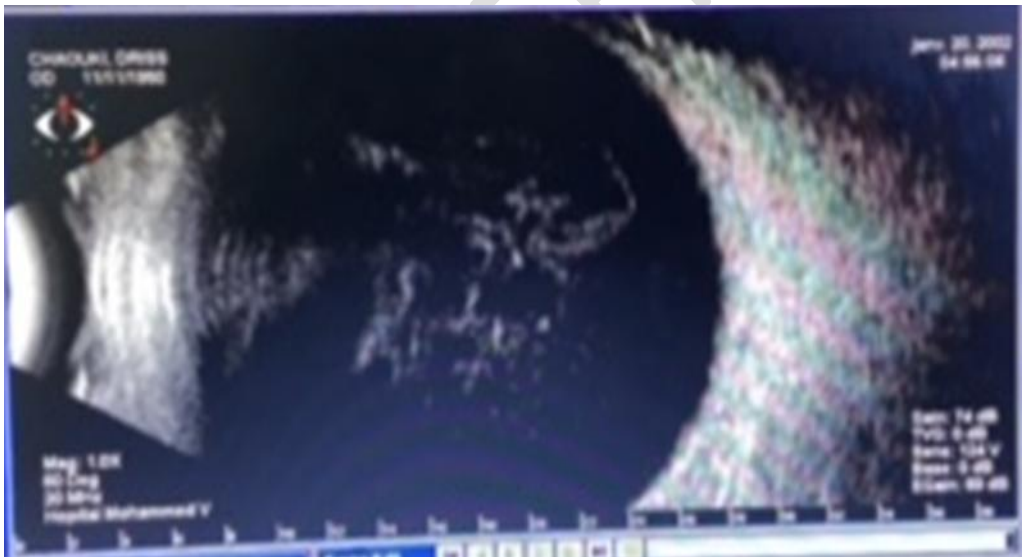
B-mode ocular ultrasound showing the presence of vitreous echoes.
